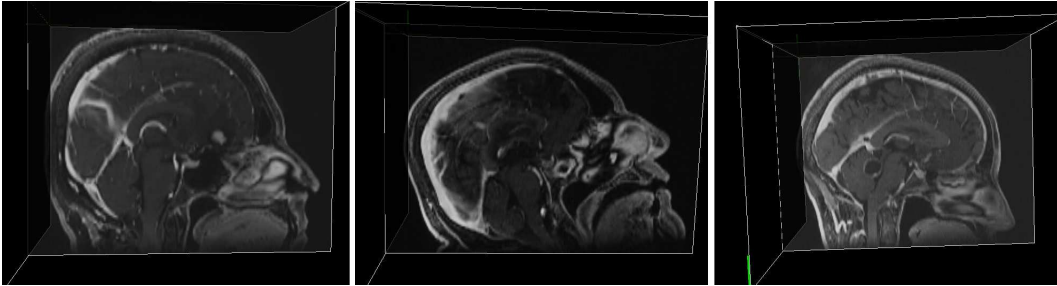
Axial tilt problem in MRI volume acquisition: Normal (left), tilt up (middle), tilt down (right).
